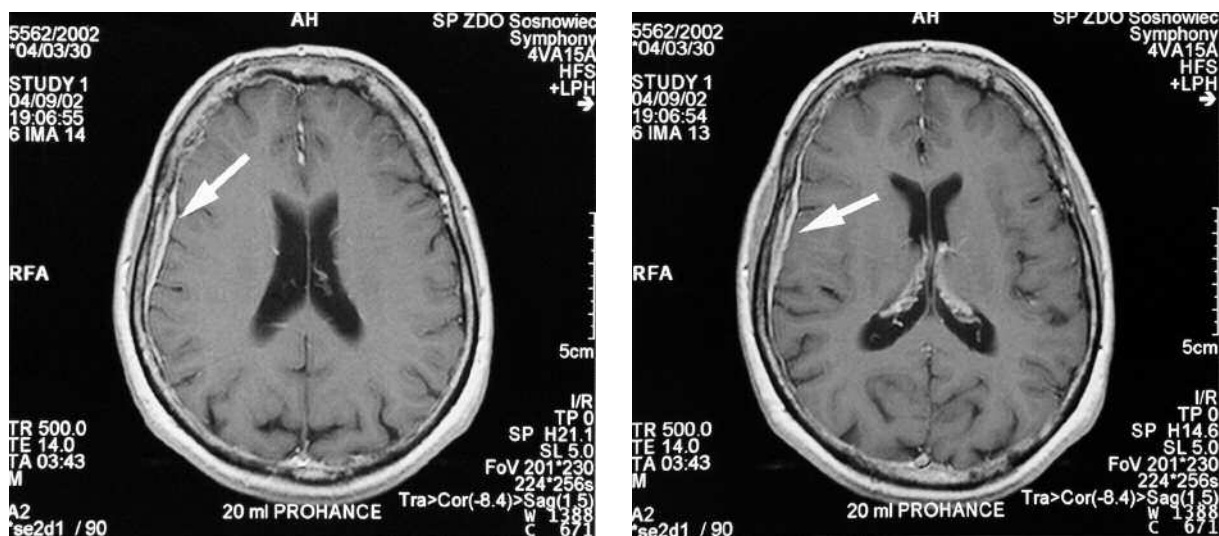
T1-weighted MRI axial images with contrast enhancement on admission
